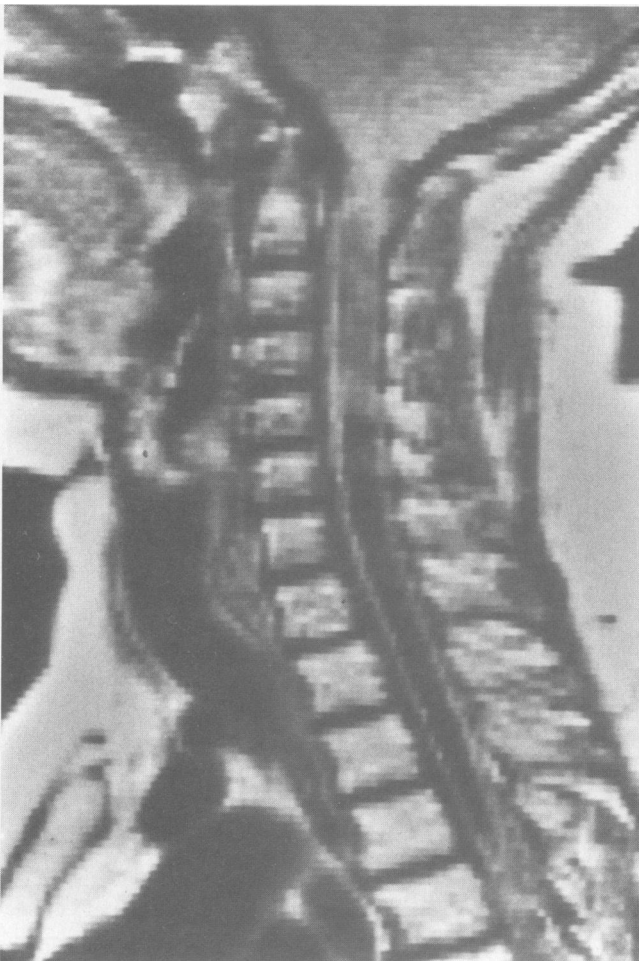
Case 8: A sagittal magnetic resonance image shows the intramedullary cavity.
